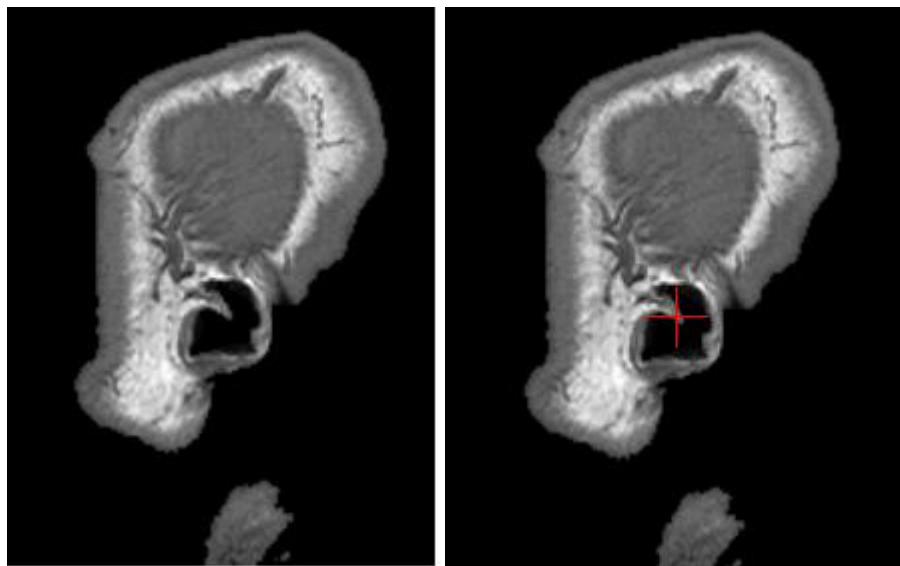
Highest part of the crus of helix, and MRI landmark location
